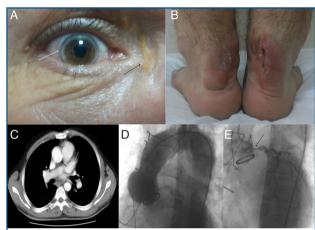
(A) Arcus senilis in the right cornea (white arrow) and xanthelasma in the right palpebra (black arrow); (B) Xanthoma of Achilles tendons after operation; (C) Contrast-enhanced computed tomography images showing diffuse calcium plaques in the ascending aorta (arrow); (D) Focal aneurismatic dilatation of aortic root is seen in the aortography; (E) Left main coronary artery lesion with significant ostial stenosis (arrow).
